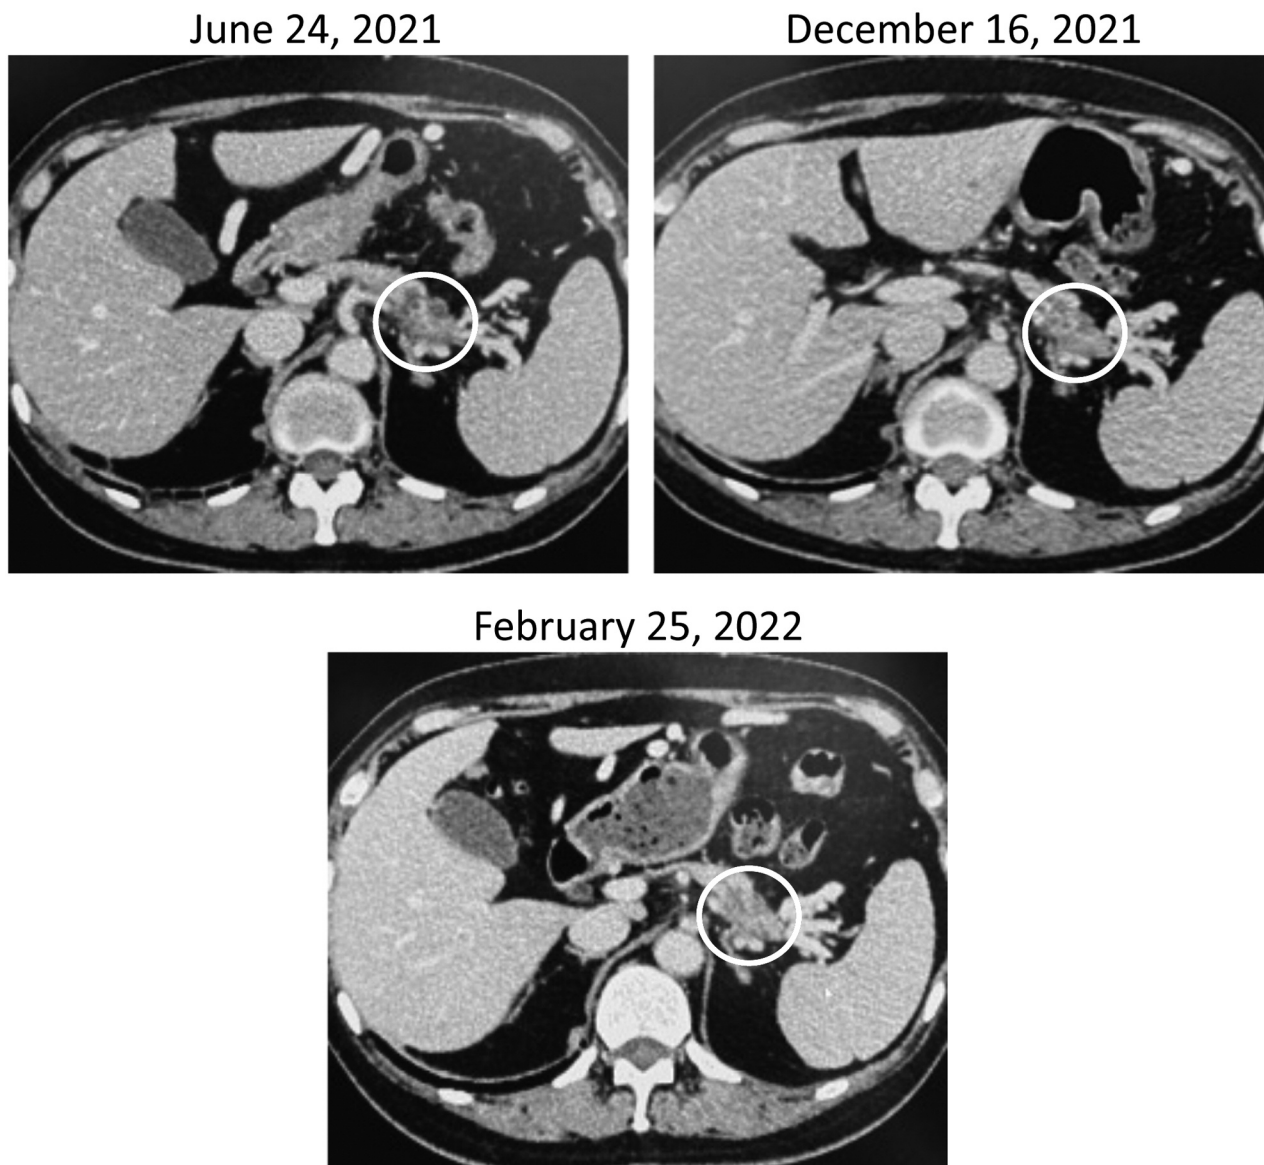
Computed tomography findings of pancreatic cancer before and after *o*-rMETase was started on September 1, 2021.
